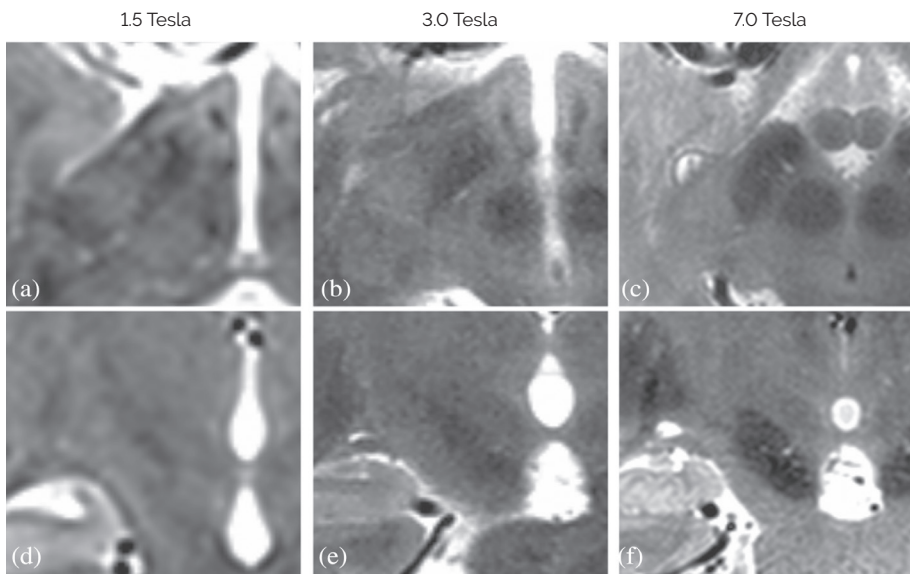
Examples of STN imaging using T2-weighted MRI in three different field strengths. Figures (a) – (c) show axial cross-sections of the STN in 1.5 T, 3.0 T and 7.0 T MRI respectively. Figures (d) – (f) show coronal cross-sections of the STN in 1.5 T, 3.0 T and 7.0 T MRI respectively.
